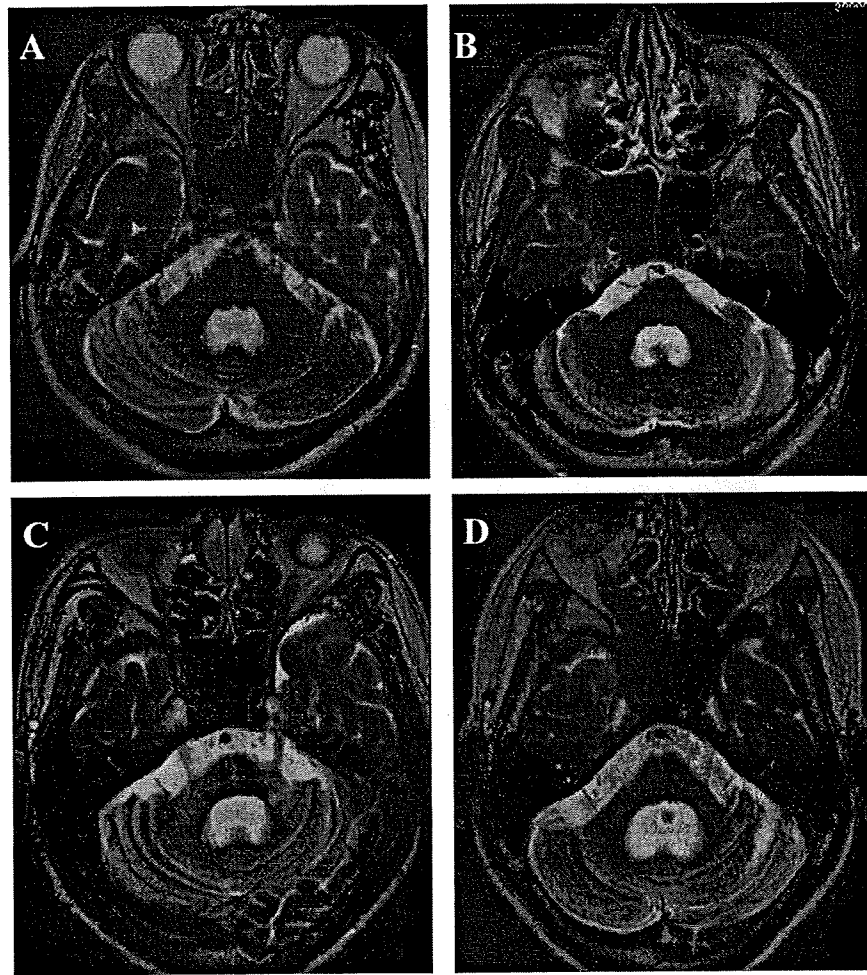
T2-weighted MR images (axial images) in patients with MSA-C (A–D). The degree of brain atrophy in the cerebellum, pons, and middle cerebellar peduncles was various as follow; mild to moderate (A and B) and severe (C and D). Abnormal signal hyperintensity in the pontine base was clearly observed (C).
